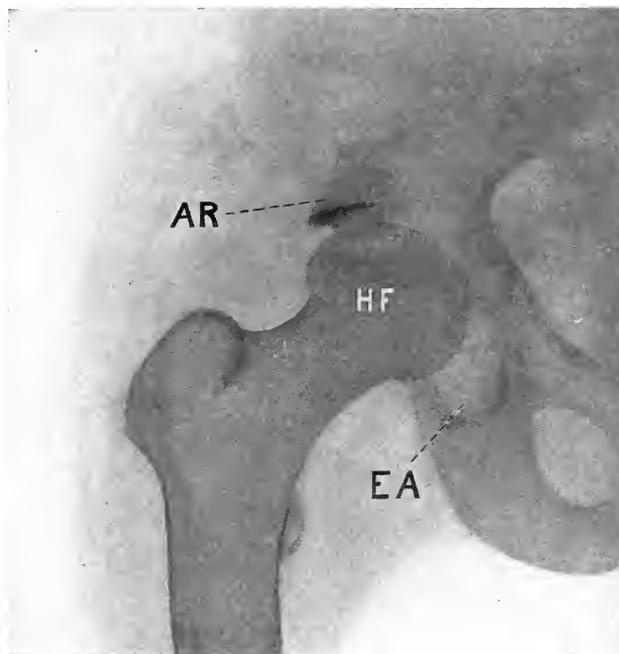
X-RAY OF FRACTURE OF RIM OF ACETABULUM.
